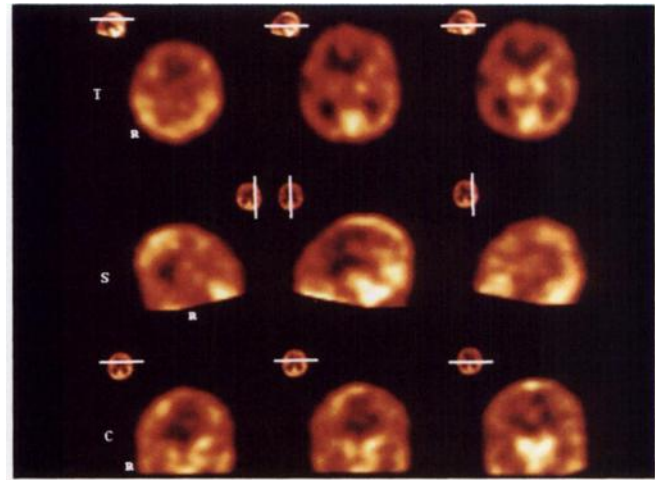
Multiple defects involving both hemispheres (Patient 12). This newborn had cardiac arrest prior to ECMO, necessitating cardiopulmonary resuscitation. SPECT reveals multiple areas of decreased perfusion in the right frontal, temporo-occipital, left frontal, parietal and right thalamus. The neonate had clinical features of hypoxic-ischemic encephalopathy and CT depicted multiple hypoxic regions, which was more obvious than SPECT (Fig. 9).
